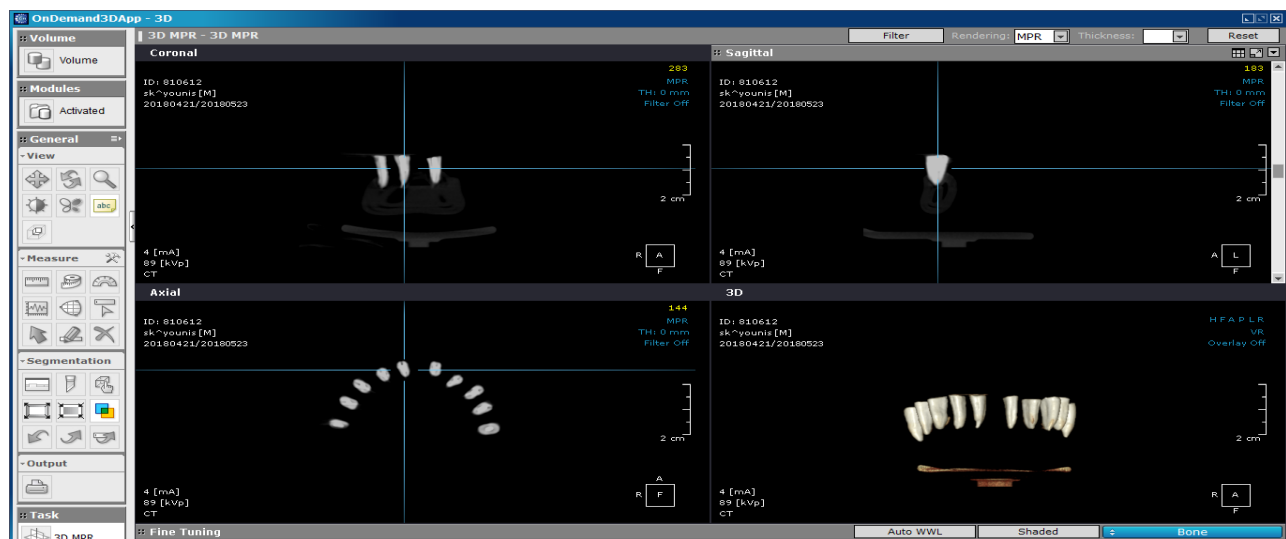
The CBCT images of the obturated tooth are shown in 3D view- coronal, sagittal, axial
